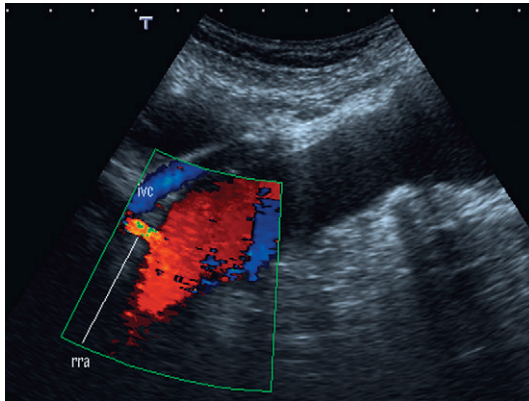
Colour flow Doppler of the aorta in coronal view. There is marked atheroma of the aortic wall. The origin of the right renal artery is demonstrated beneath the inferior vena cava. The left renal artery was occluded.
